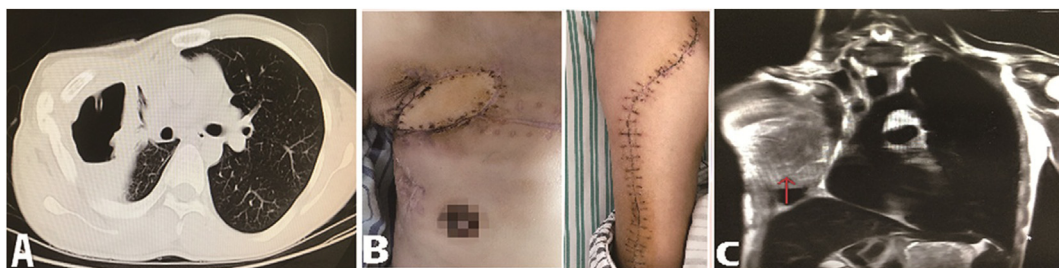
Clinical images of case-2. A. The chest computed tomography at admission showed right hydropneumothorax with drainage tube placed in the right thoracic cavity. B. The myocutaneous flap was active, and the incision healed well after surgery. C. The chest magnetic resonance imaging indicated that the empyema cavity and bronchopleural fistula were successfully blocked (red arrow).
